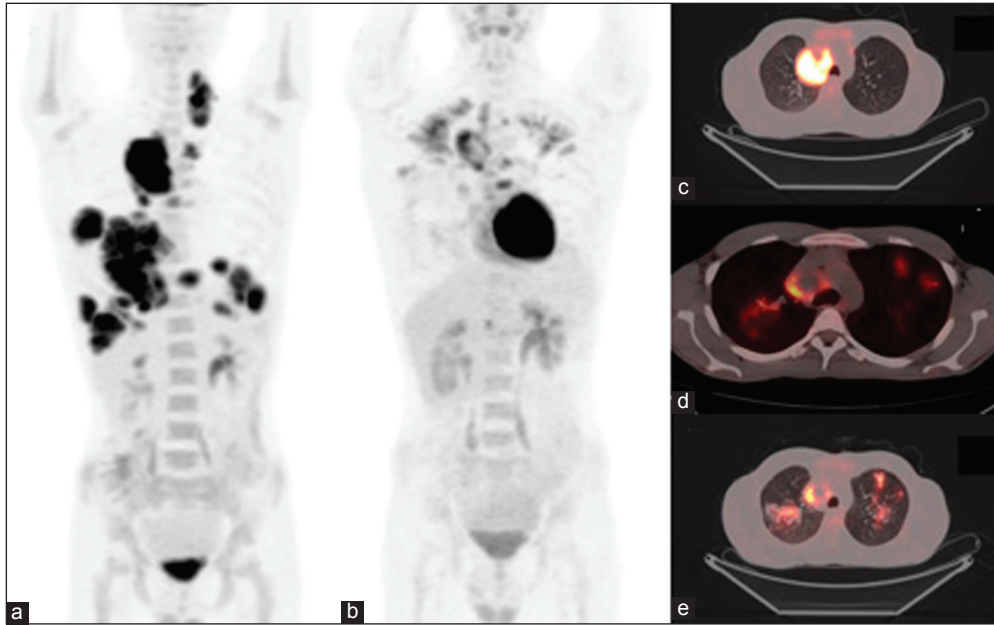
A 22-year-old male patient with newly diagnosed Hodgkin's lymphoma diagnosed from left supraclavicular lymph nodal biopsy underwent staging positron emission tomography/computed tomography (PET/CT) study. PET/CT scan revealed intensely fluoro-deoxy-glucose (FDG) avid multiple left supra and infra clavicular and right paratracheal mass, left lower paratracheal, subcarinal lymphnodes along with lymphomatous involvement of lower lobe of the right lung and also few FDG avid focal lesions in spleen (a) Diffuse homogenous marrow uptake of FDG was seen consistent with cytokine induced bone marrow hyperplasia. Subsequently he underwent bilateral iliac crest bone marrow biopsies that did not reveal marrow involvement. No calcification or necrosis was noted in any of the lymph nodes or spleen was noticed. Patient was not known to have any past history of tuberculosis. After four cycles of adriamycin (doxorubicin), bleomycin, vinblastine and dacarbazine (ABVD) chemotherapy, he developed a cough with expectoration and fever with evening rise of temperature for 20 days, which was not revealed with conventional antibiotic therapy. Follow-up PET/CT revealed disappearance of metabolically active disease in left supra and infra clavicular lymph nodes and lower lobe of the right lung. However, intensely FDG avid paratracheal mass showing central necrosis was seen along with few subcarinal lymph nodes and a focus in spleen (b). New infiltrates with mild FDG uptake were noted in bilateral lung fields suggestive of infectious pathology. On the basis of patient's symptomatology and necrotic mediastinal lymph nodes along with bilateral lung infiltrates (c-e) tubercular pathology was suspected. Subsequently patient underwent guided biopsy of the necrotic mediastinal lymph node, which revealed caseation necrosis and granuloma formation and cultures revealed Mycobacterium Tuberculosis. Subsequently patient was started on anti-tuberculosis treatment with relief of symptoms and clinical improvement. Learning points in this case are that in a tuberculous endemic country like India, TB can always co-exist with lymphoma and should be suspected when the symptomatology along with necrotic mediastinal lymph nodes and lung infiltrates are seen on interim PET/CT scan
